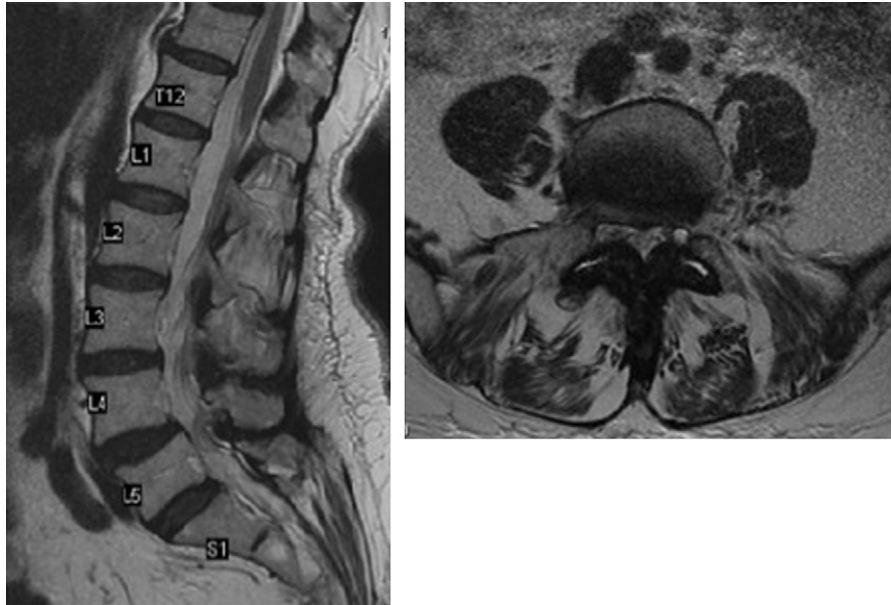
(Left) T2 sagittal spine magnetic resonance imaging (MRI). (Right) Axial MRI demonstrating foraminal stenosis and left facet cyst.
